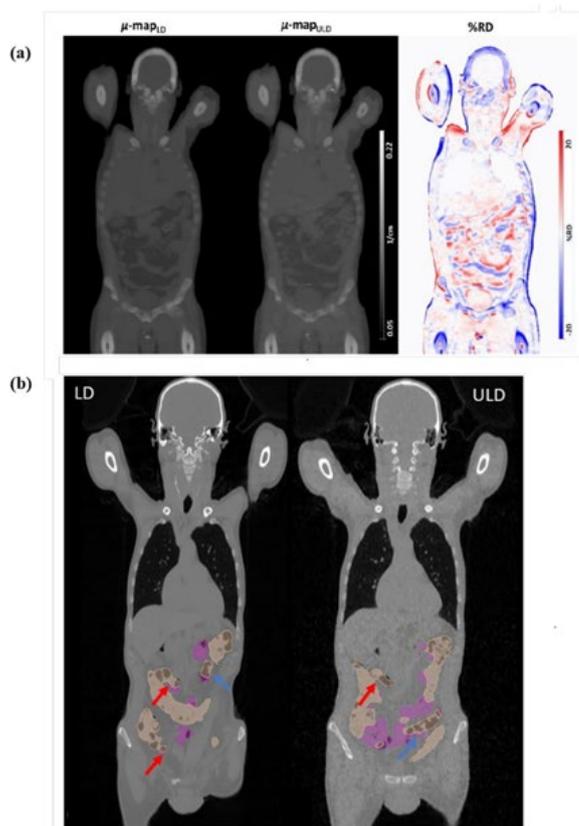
(a) Attenuation maps from low-dose (LD) and ultra-low-dose (ULD) CT scans, with the corresponding relative difference (%RD) map. (b) Coronal LD (left) and ULD (right) CT slices with automatic segmentations of colon (beige) and small bowel (purple). Red arrows highlight displaced air-related protrusions, and the blue arrow indicates misclassification between small bowel and colon.
